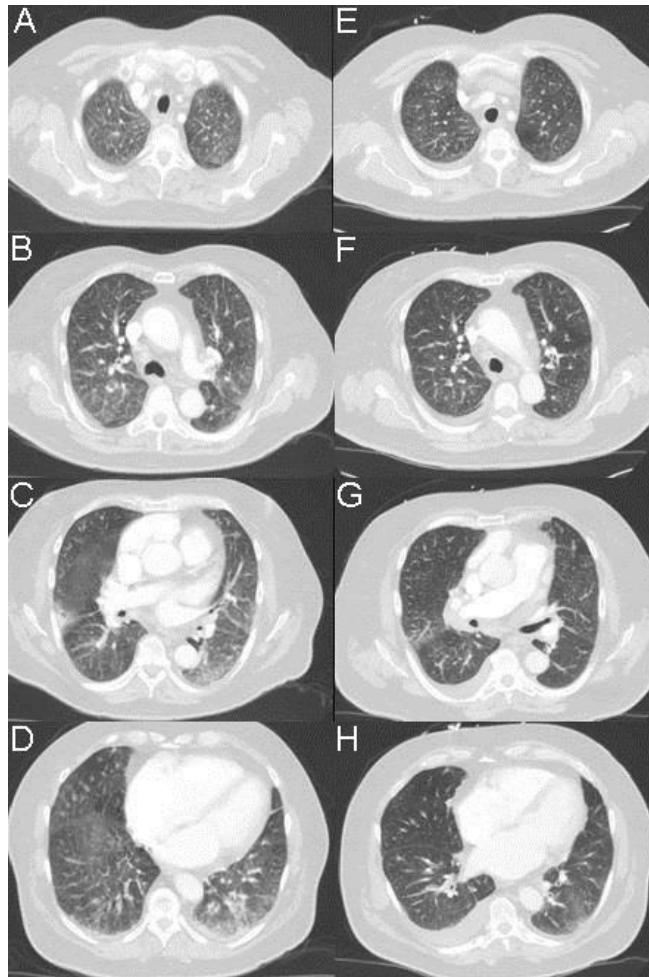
A-D: Thoracic CT scan with contrast from present admission. E-H: Thoracic CT from admission 4 months earlier for comparison.
